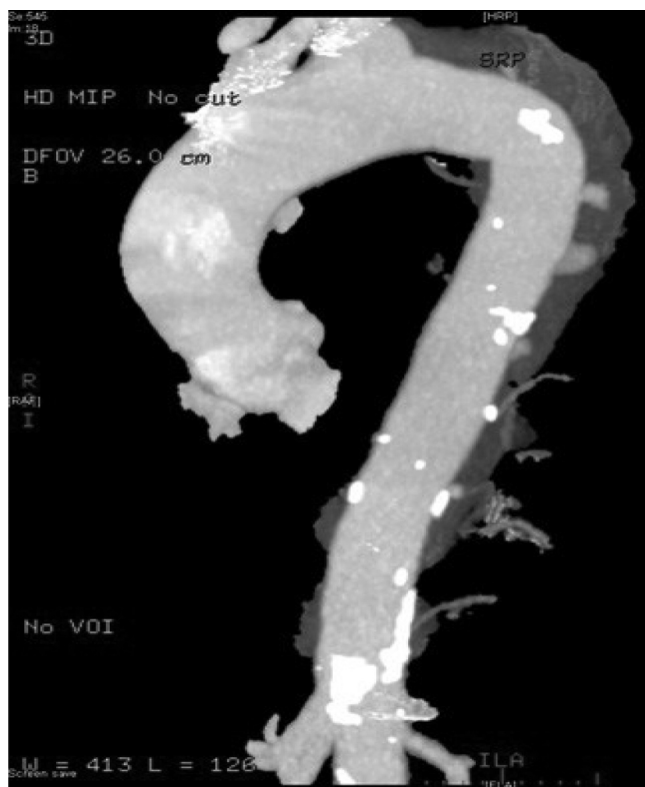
Contrast-enhanced CT scan of the thoracic aorta demonstrating several small collections of contrast in the intramural hematoma representing inflow from the intercostal arteries. There is good perfusion to the celiac axis superior mesenteric artery and renal arteries.
